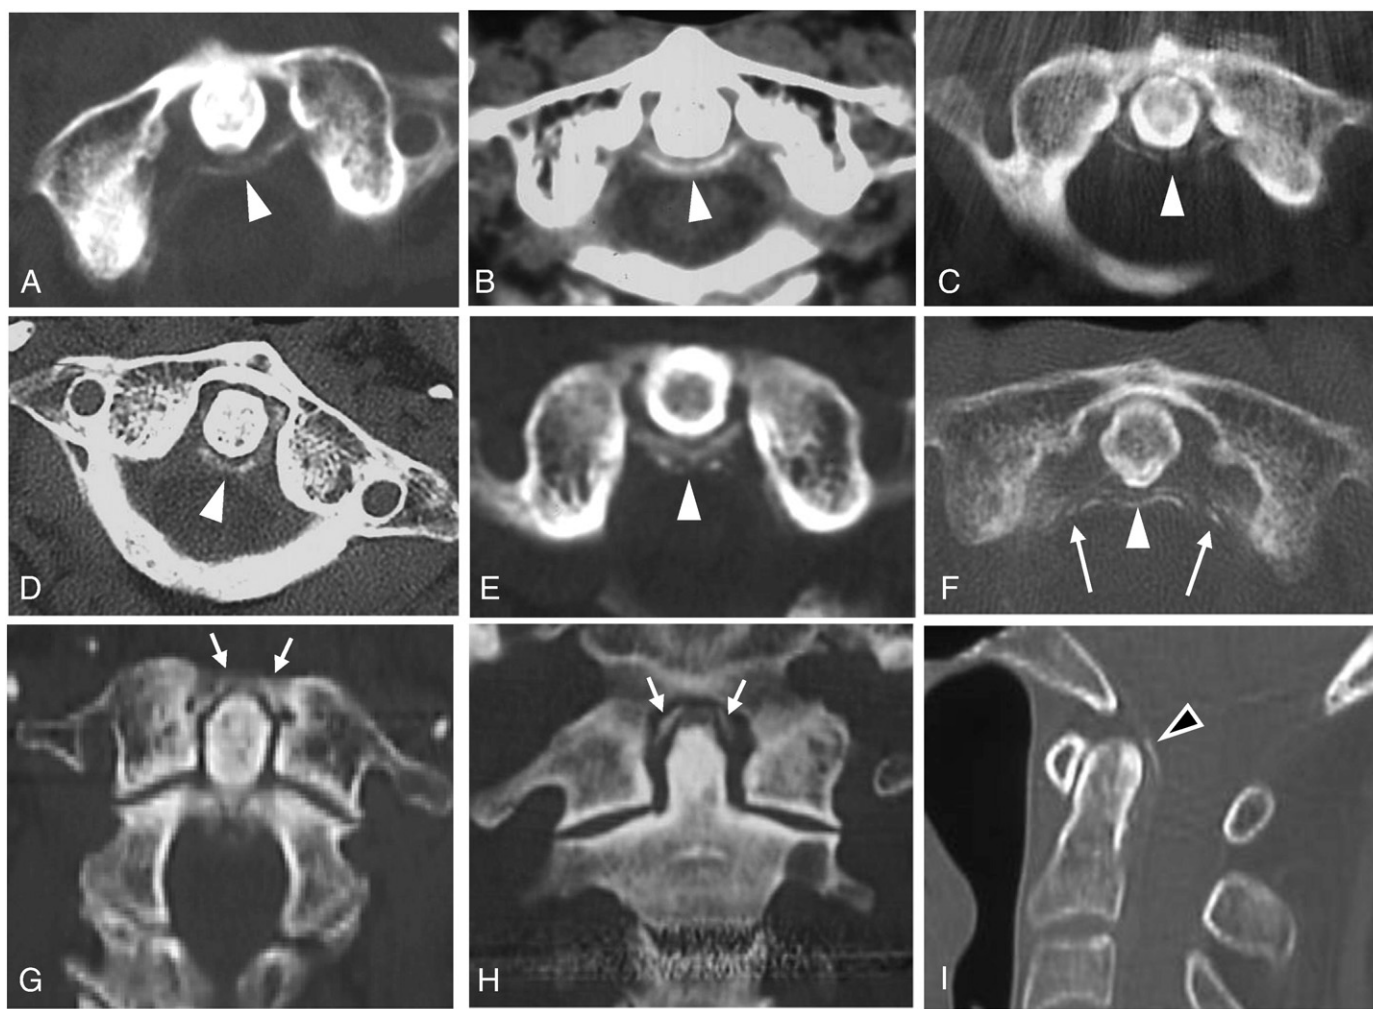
Axial (A–F), coronal (G, H), and sagittal (I) views of the cervical CT scan at the C1/C2 level showed linear calcifications of the transverse ligament (A–F; arrowheads), alar ligament (F; long arrows), apical ligament (G, H; short arrows), and superior longitudinal fibres of the cruciate ligament (I; black arrowhead) suggesting CPPD deposition. (A) Patient 2. (B) Patient 4. (C) Patient 5. (D) Patient 7. (E) Patient 8. (F) Patient 11. (G) Patient 10. (H) Patient 13. (I) Patient 11.
